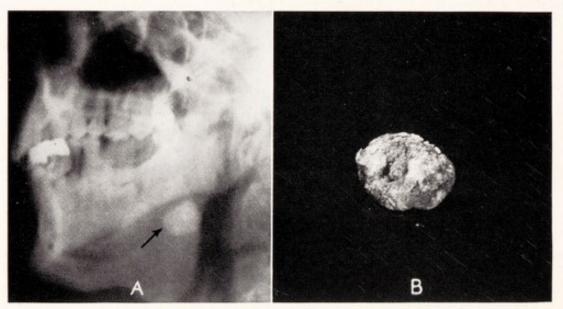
Sialolith. A, X-ray of a stone lying below the edge of the jawbone. B, Stone after removal.
